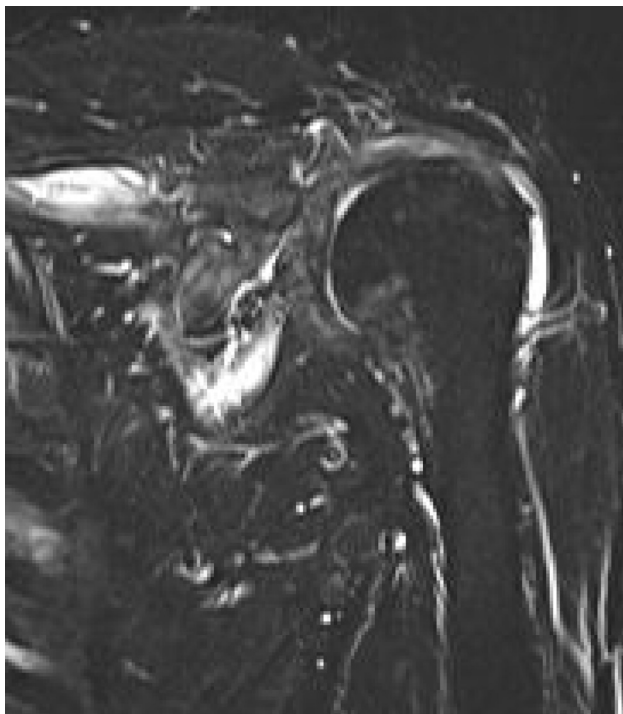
MRI on the sixth postoperative month showing no rotator cuff injury and high intensity of T2-STIR of the infrapinatus. MRI, magnetic resonance imaging; T2-STIR, T2-weighted short tau inversion recovery.
